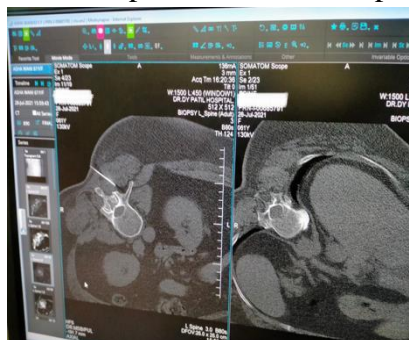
CT image after the introduction of 22G spinal needle
